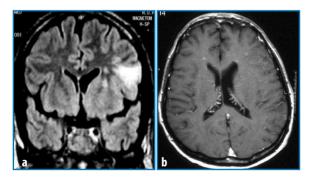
Immune reconstitution vasculitis confirmed by brain biopsy. a Fluid-attenuated inversion recovery MR image obtained in the coronal plane shows an infarct in the left middle cerebral artery territory. b Gadolinium-enhanced T1-weighted MR image obtained in the axial plane shows punctiform bilateral enhancement
